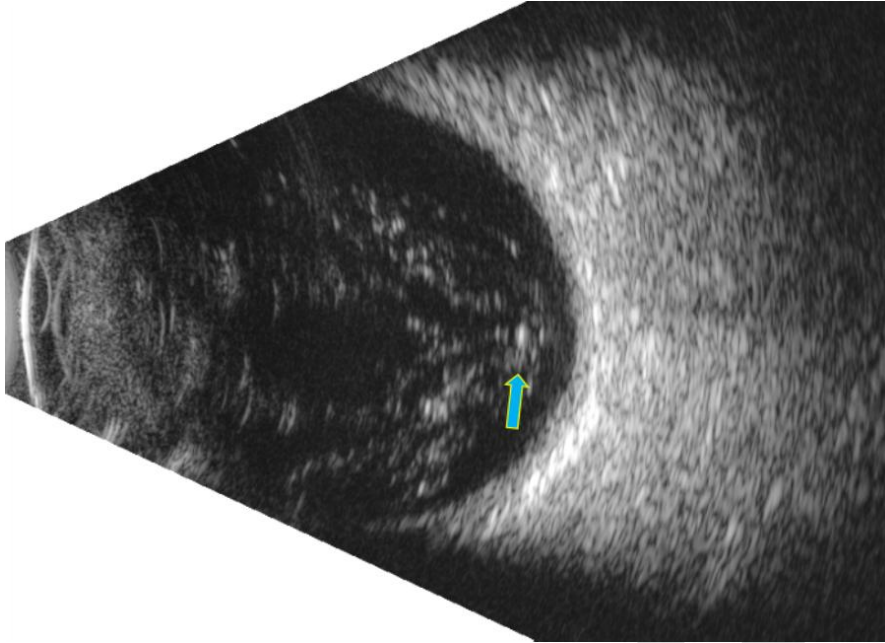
B-scan Ultrasonography image showing significant refractile vitreous deposits representing adenocarcinoma metastasis.
